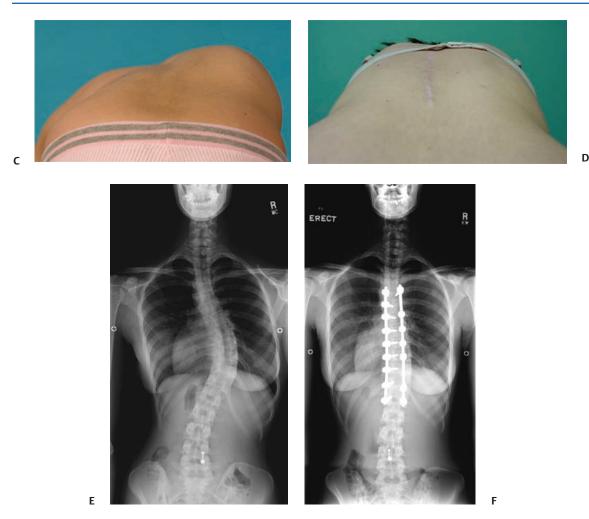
(*Continued*) (C) Preoperative photograph of the patient in the forward-bend position. (D) Two-year postoperative of the patient in the forward-bend position. (E) Preoperative posteroanterior (PA) X-ray film. (F) Two-year postoperative PA X-ray film.
